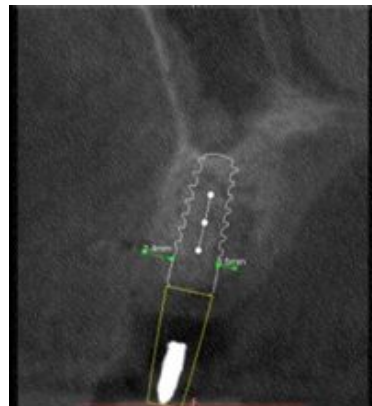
Pre-operative evaluation of angular measurement of the proposed implant by software analysis of CBCT scan.
